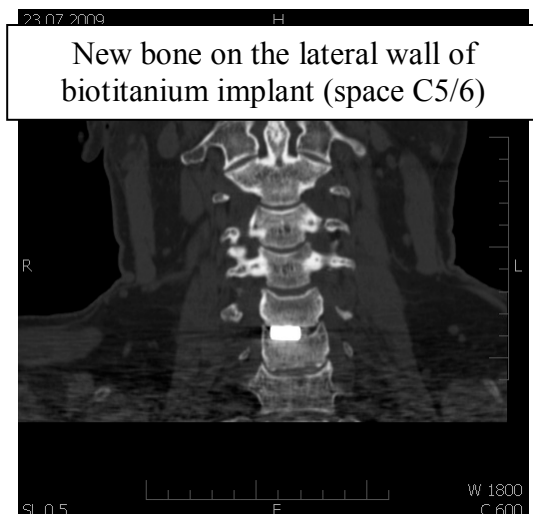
CT after 12 months with signs of migration of osteoblasts along the anterior and lateral walls of the implant, section C5/6
